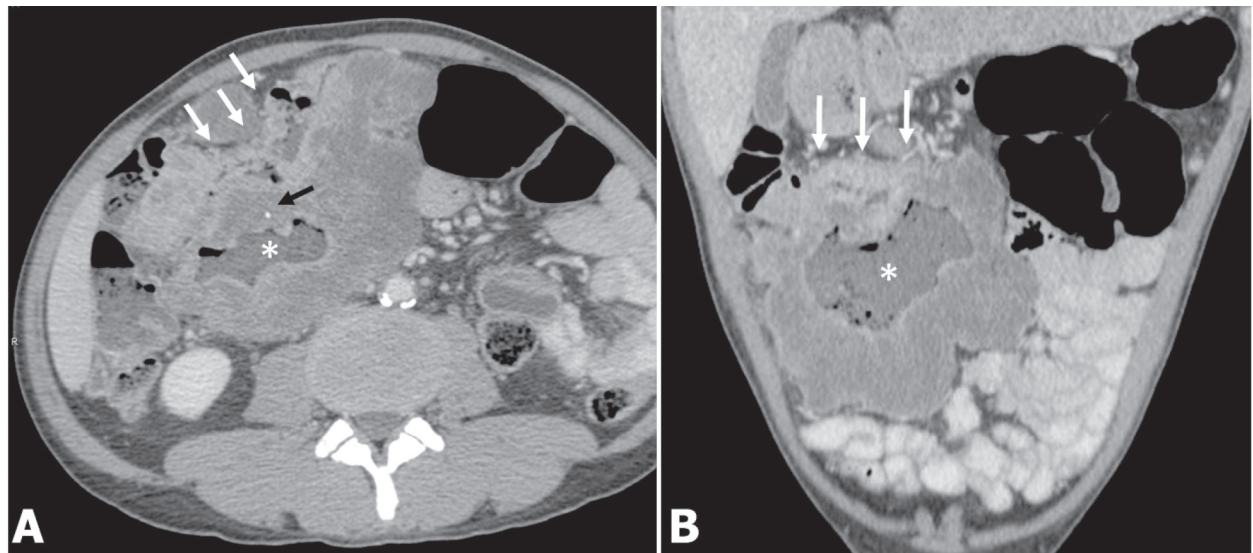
CT appearances of mucinous rectosigmoid CA.
